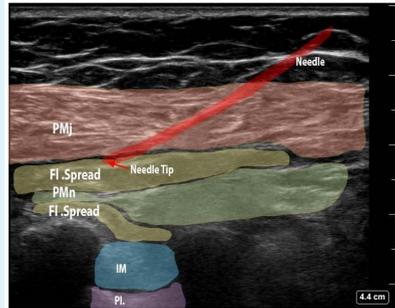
Ultrasound image showing needle and anesthetic spread with false-color overlay.
